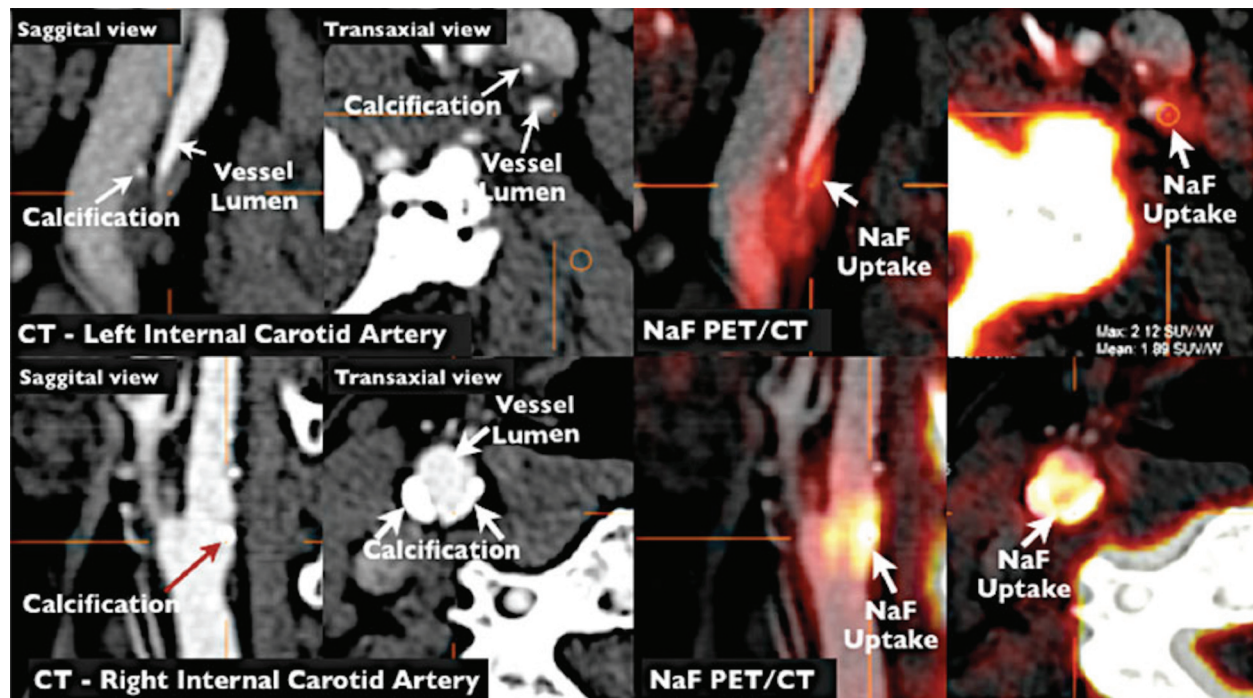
Imaging of vulnerable plaque by positron emission tomography/computed tomography (PET/CT). NaF PET/CT imaging of left and right internal carotid arteries of active calcification in a 72-year-old symptomatic patient evaluated at the University of Ottawa Heart Institute. Upper row: evidence of NaF uptake with small foci of calcification on CT in the left internal carotid symptomatic culprit vessel. There is a mismatch between the region of NaF uptake and calcification on CT. Lower row: evidence of calcium nodules with matched NaF uptake at the right internal carotid artery. Reproduced by permission of Springer from: Cocker MS, Mc Ardle AB, Spence JD, Lum C, Hammond RR, Ongaro DC, McDonald MA, Dekemp RA, Tardif JC, Beanlands RS: Imaging atherosclerosis with hybrid [18F]fluorodeoxyglucose positron emission tomography/computed tomography imaging: what Leonardo da Vinci could not see. *J Nucl Cardiol* 2012, 19(6): 1211–1225.
